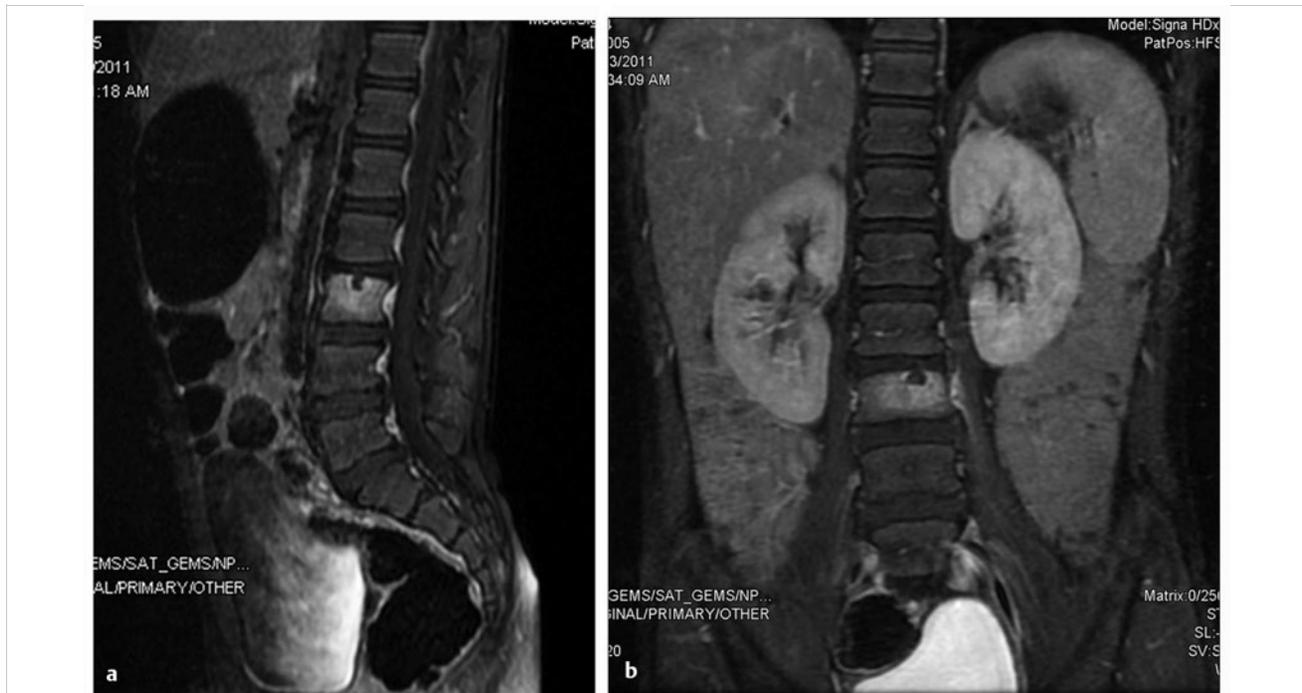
(a,b) Pyogenic vertebral osteomyelitis. Six-year-old male had 2-week history of low back pain with sitting that resolves when lying down. There are no fevers. T1 post-contrast MRI discloses increased signal intensity within the L3 vertebral body with minimal signal change in the L2–3 disc. Blood cultures remained negative and patient did not respond to a 2-week course of IV Clindamycin. He was switched to Vancomycin and Rocephin with subsequent improvement.
